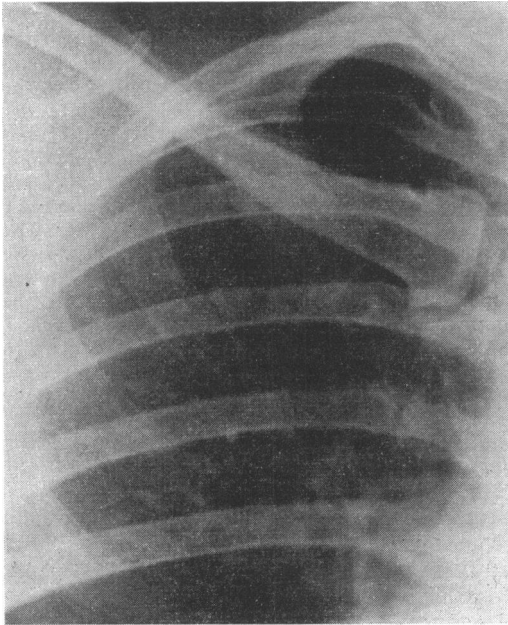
Case 1 Radiograph, February 1959, showing upper zone of right lung; the round shadow had been present, with little change, for three years
